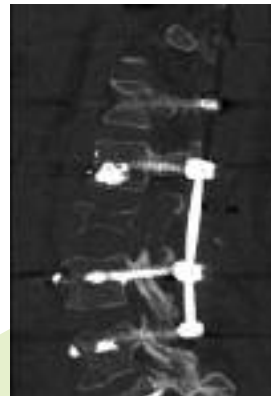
Lateral CT Scan
